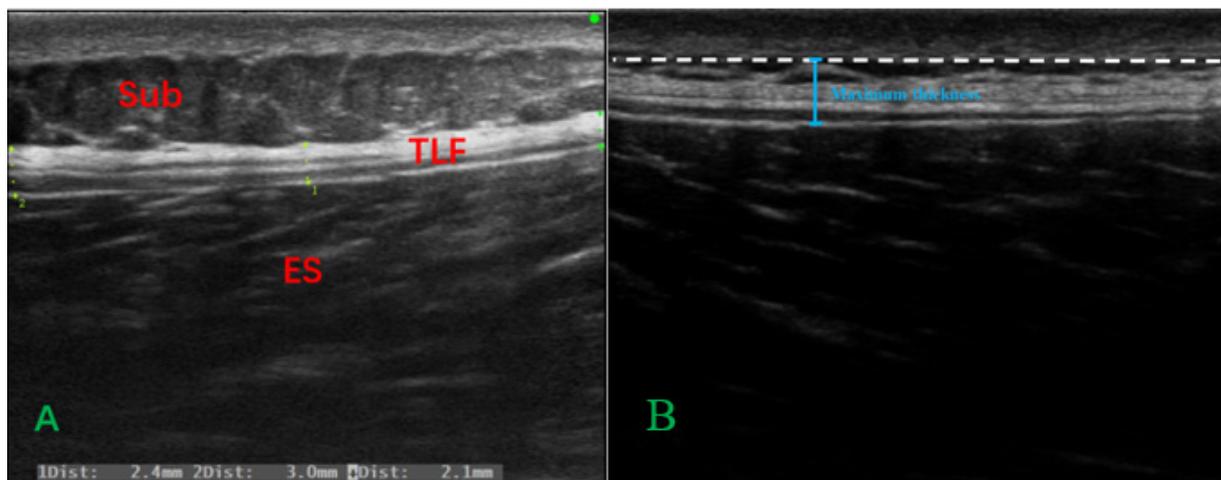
Ultrasound image measurement of mean and maximum values of TLF thickness. (A) Mean value of TLF thickness, (B) Maximum value TLF thickness.
